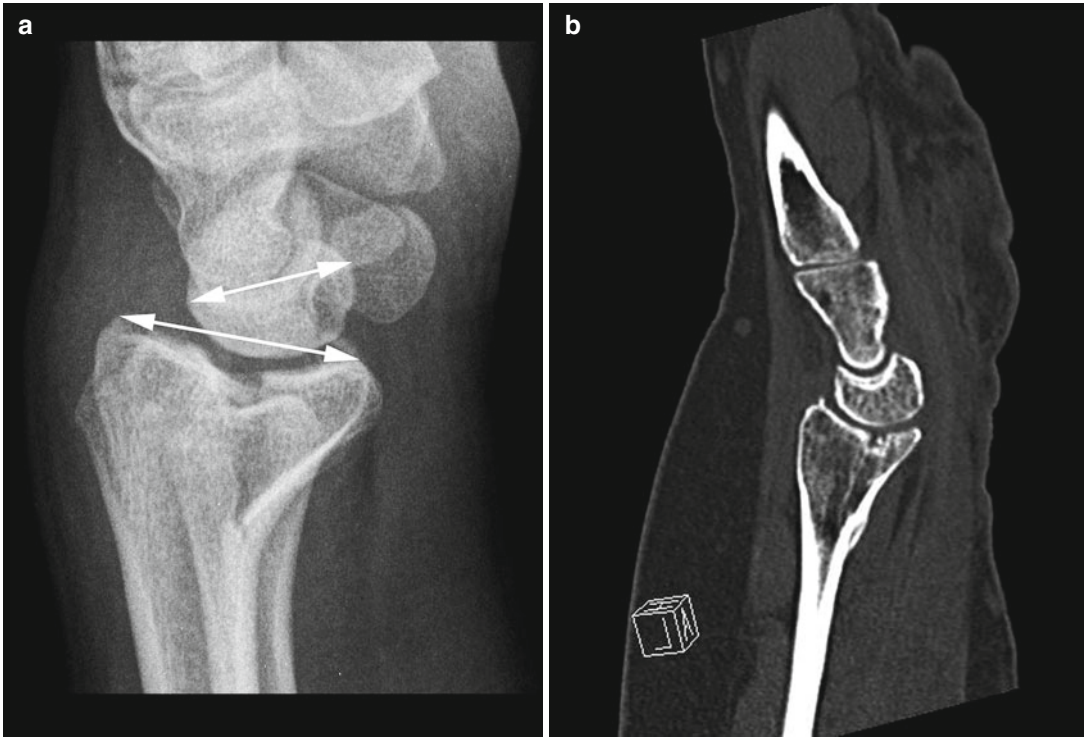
Widening of the AP distance of the distal radius (a) Lateral radiograph (b) CT scan. The *short arrow* represents the AP diameter of the normal lunate.
